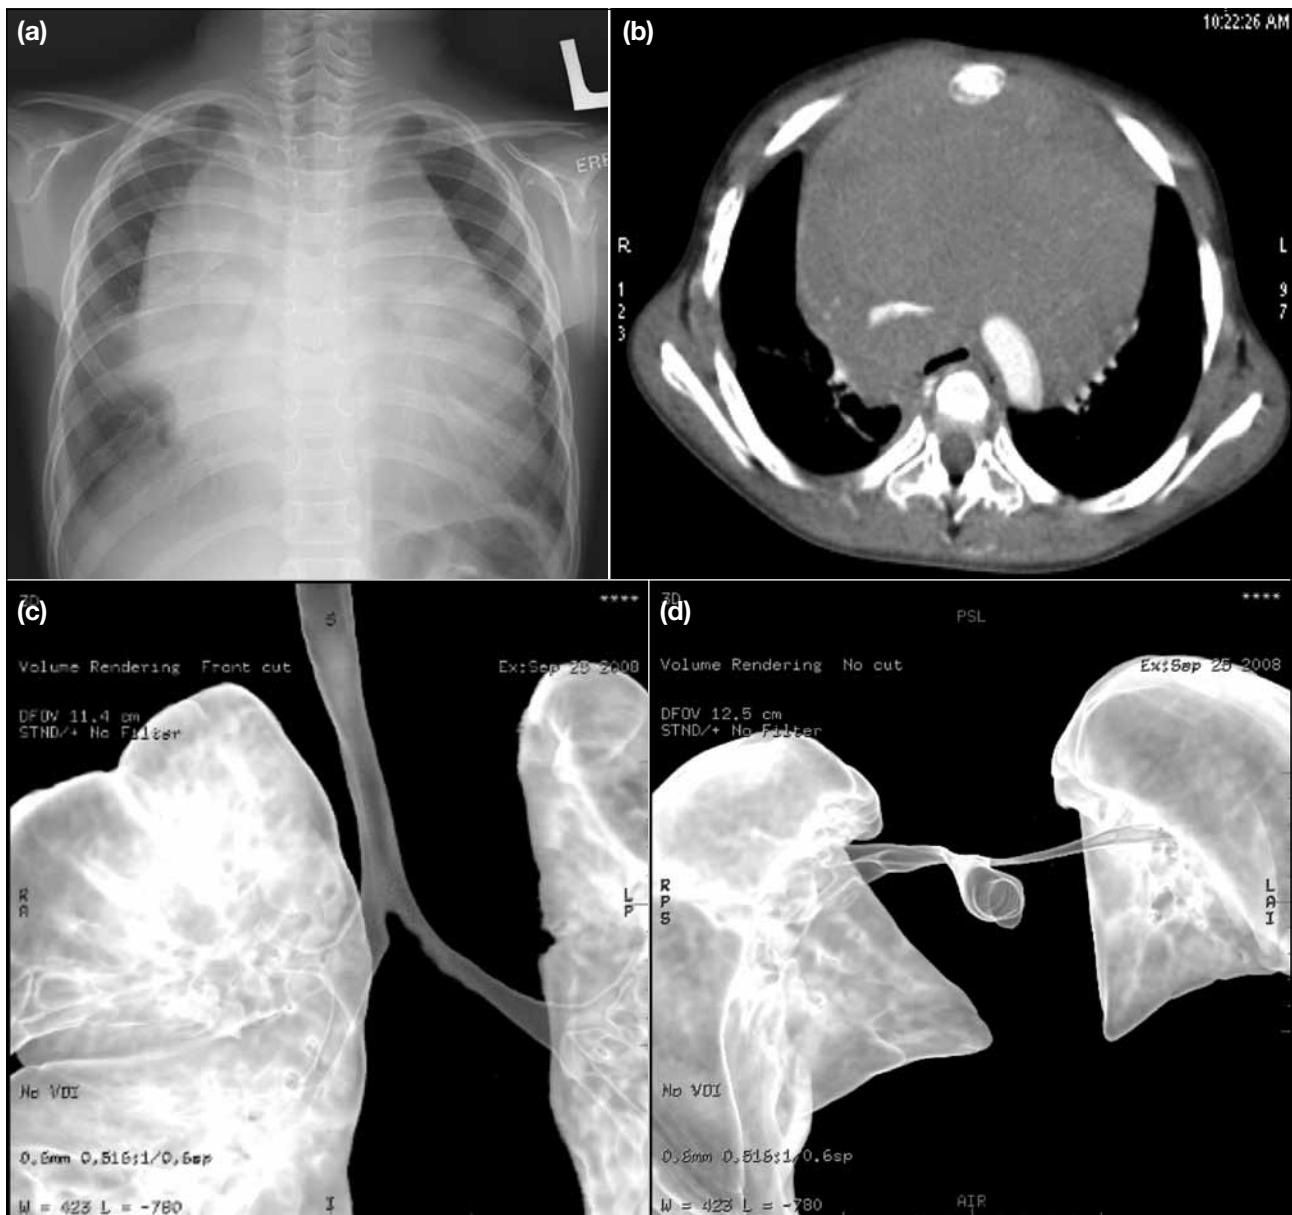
A 5-year-old patient presented with dyspnoea and developed cardiac arrest upon sedation for percutaneous biopsy. (a) A chest radiograph reveals a large mediastinal mass at presentation. (b) Contrast-enhanced computed tomographic thorax reveals a large anterior mediastinal mass compressing onto the trachea. (c and d) Volume-rendering reformatted images demonstrate severe compression onto the distal trachea and proximal left main bronchus (significant decrease in tracheobronchial area and diameter).
